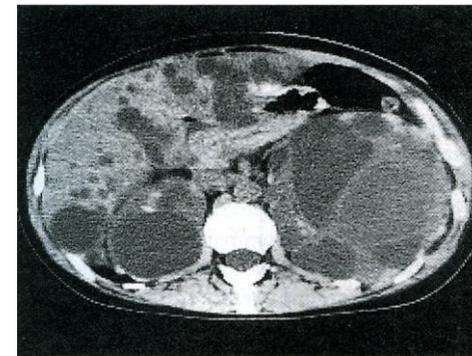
CT scan revealing bilateral congenital polycystic kidneys, larger on the patient's left (to the right of the picture). The liver also contains multiple cysts. The pancreas can be clearly seen in this view, but does not seem to contain any large cysts.
